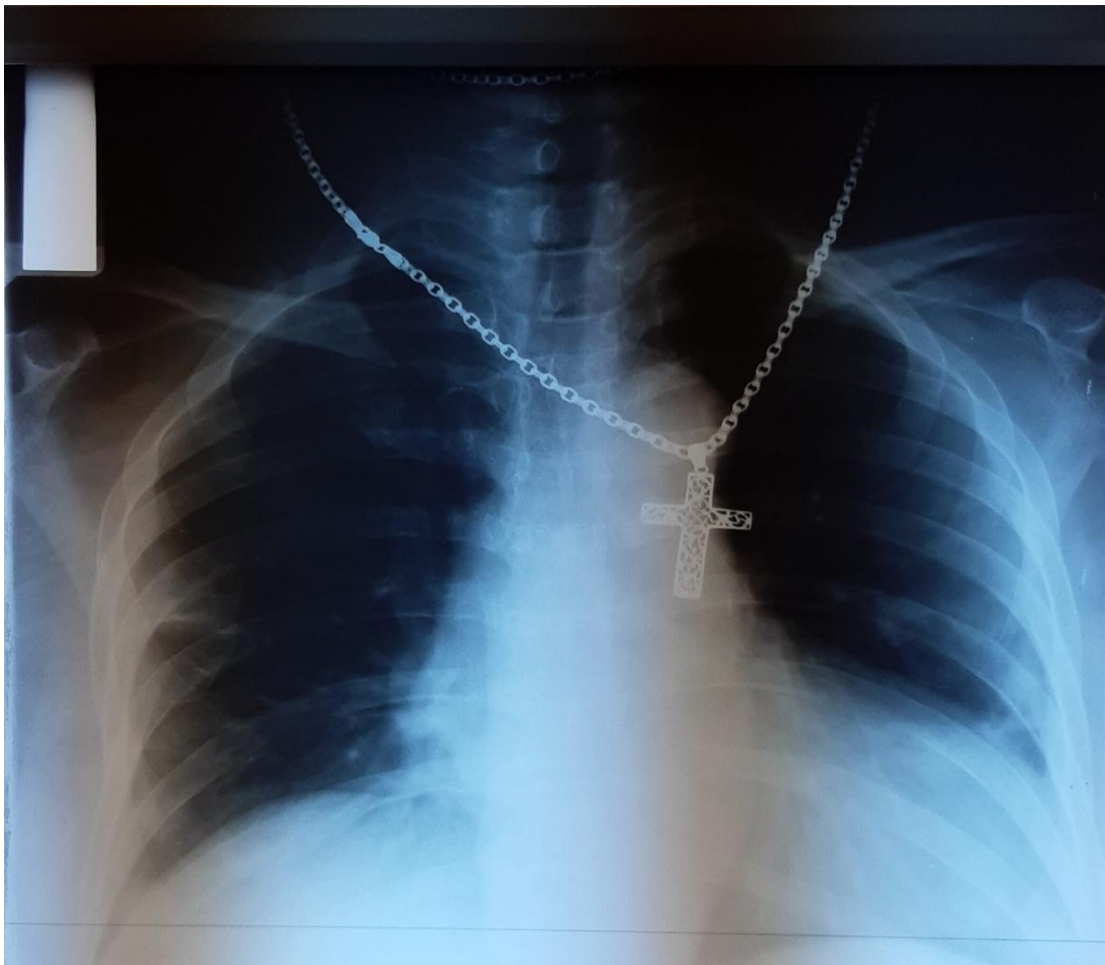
Pneumonia of the left lower lobe. Chest X-ray
